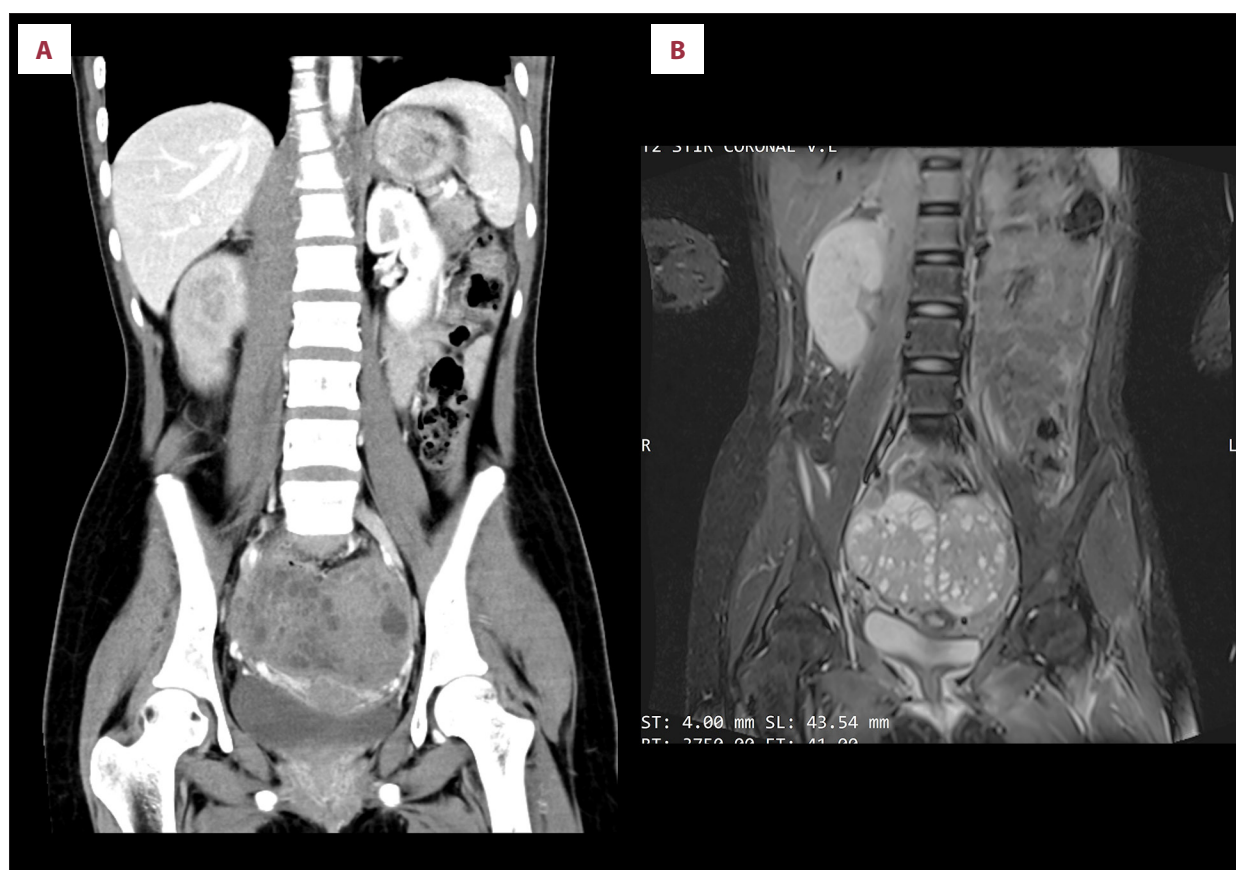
(A) Contrast-enhanced abdominal and lumbosacral computed tomography scan demonstrating compression of the T12 vertebra and a paravertebral mass extending from T11 to L3. (B) Contrast-enhanced abdominal and lumbosacral magnetic resonance image.
